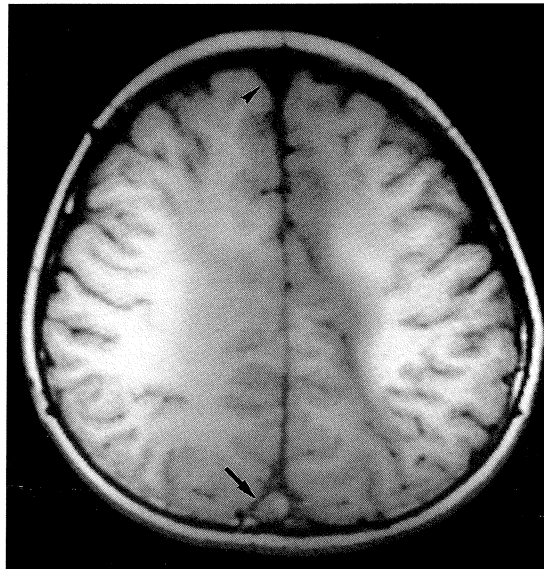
MRI T1WI axial scan of the same patient as Fig 4a confirms the presence of the clot (arrow). Compare this to the normal flow void seen in the anterior aspect of the superior sagittal sinus (arrowhead).
